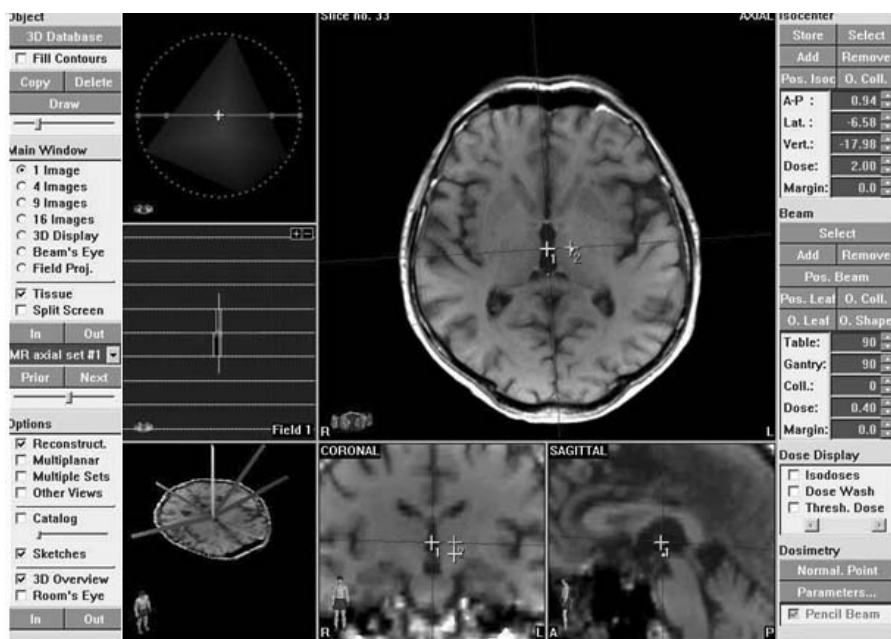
Localising the target and getting the coordinates with MRI brain.
